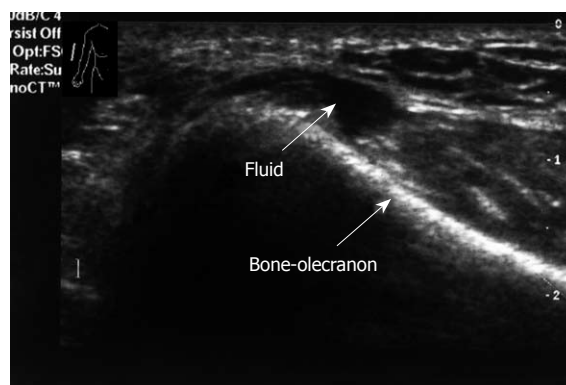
Longitudinal sonogram, right elbow. Small amount of fluid posterior aspect. No erosive changes in the bone.
